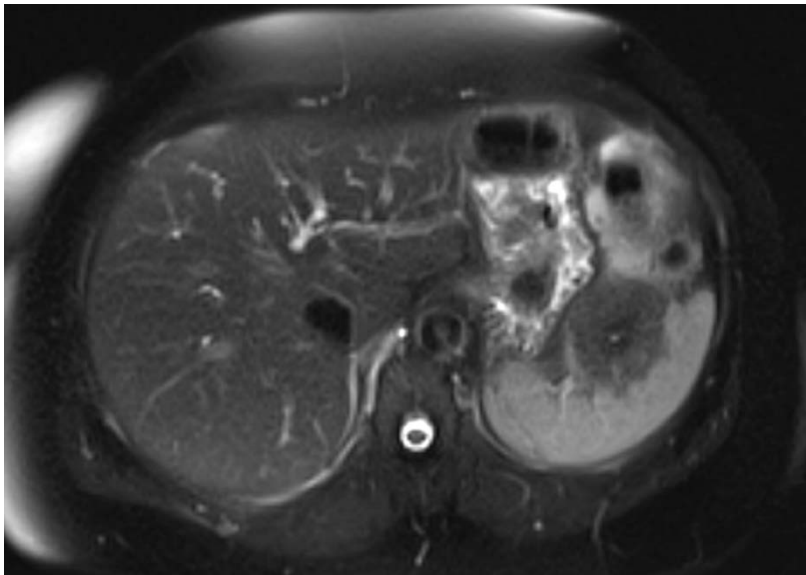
MRI of splenic mass - T1 – weighted
